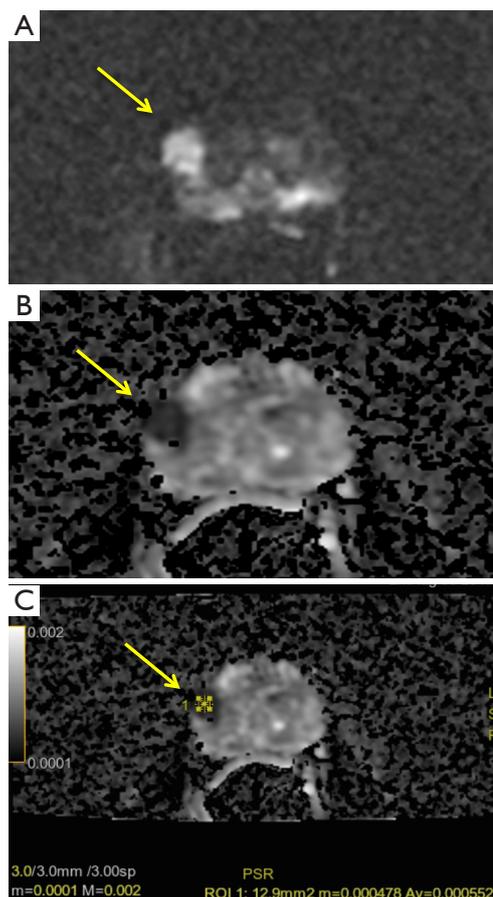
DWI (A) and ADC map (B) in patient with GS 8 prostate cancer (yellow arrow). ADC analysis (*) (C) show a low mean value (0.552×10^{-3}) consistent with the Gleason cancer grading. DWI, diffusion weighted imaging; ADC, apparent diffusion coefficient.
